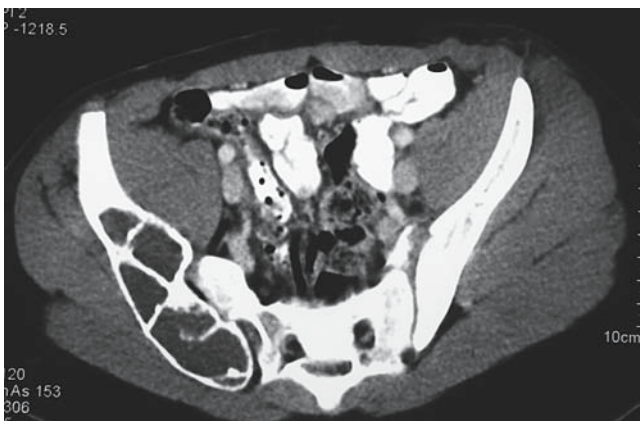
Aneurysmal bone cyst (ABC). (A) Plain radiograph demonstrates an ABC and fibrous dysplasia of the proximal third of the femur. ABCs are expansile and lytic lesions arising in skeletally immature patients with cortical thinning, as seen both medially and laterally in this patient. Approximately one-third of all ABCs arise in conjunction with another bony neoplasm, as seen here. The hip is a common site of fibrous dysplasia. (B) CT scan of the same patient demonstrates marked cortical thinning and periosteal elevation. CT scans are very good in determining bony changes. (C) CT scan shows marked involvement of the distal portion of the right ilium and entire ischium and acetabulum. This ABC shows a classic eccentric, lytic, expansile lesion with periosteal elevation and cortical thinning. This patient was treated with curettage and bone grafting. ABCs often occur in the skeletal flat bones.
